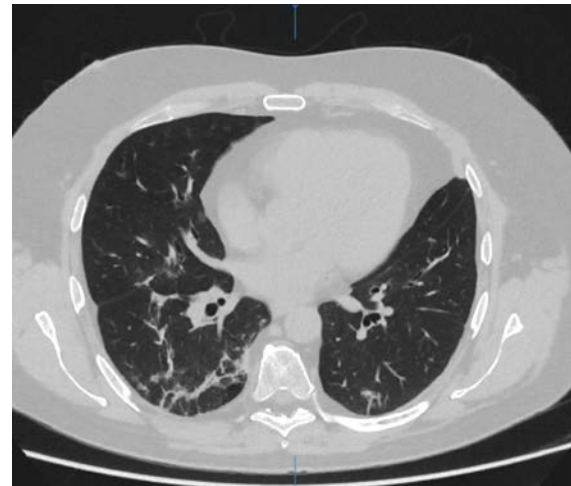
Axial thin-section unenhanced computed tomography (CT) scan shows left pleural thickening with bilateral subpleural lines and fibrous stripes in the posterior segments of the lower lobes.
